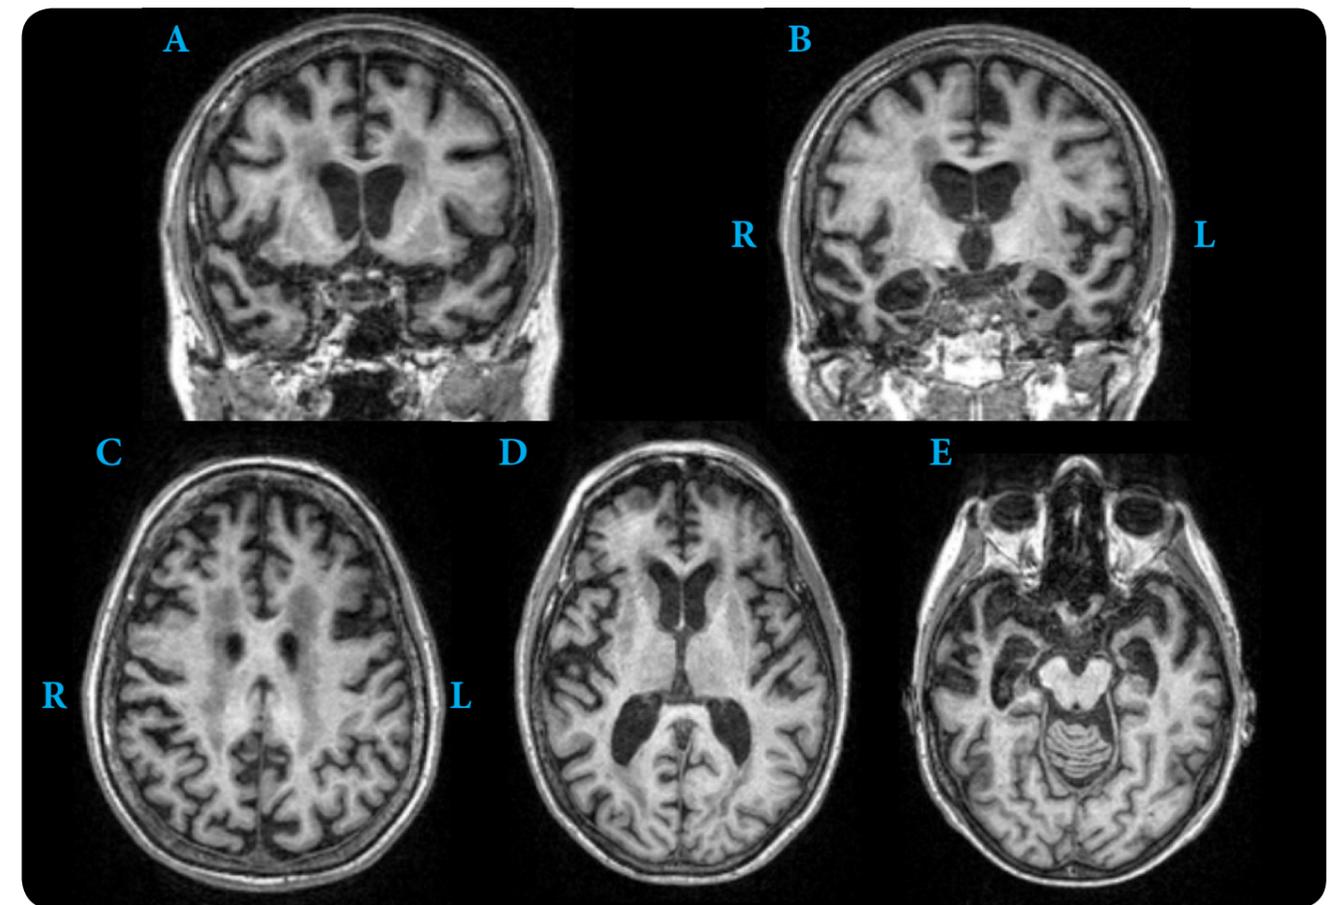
Case 3 brain MRI of Mrs. Z showing atrophy in the coronal plane (A, B) and axial plane (C, D, E.)
